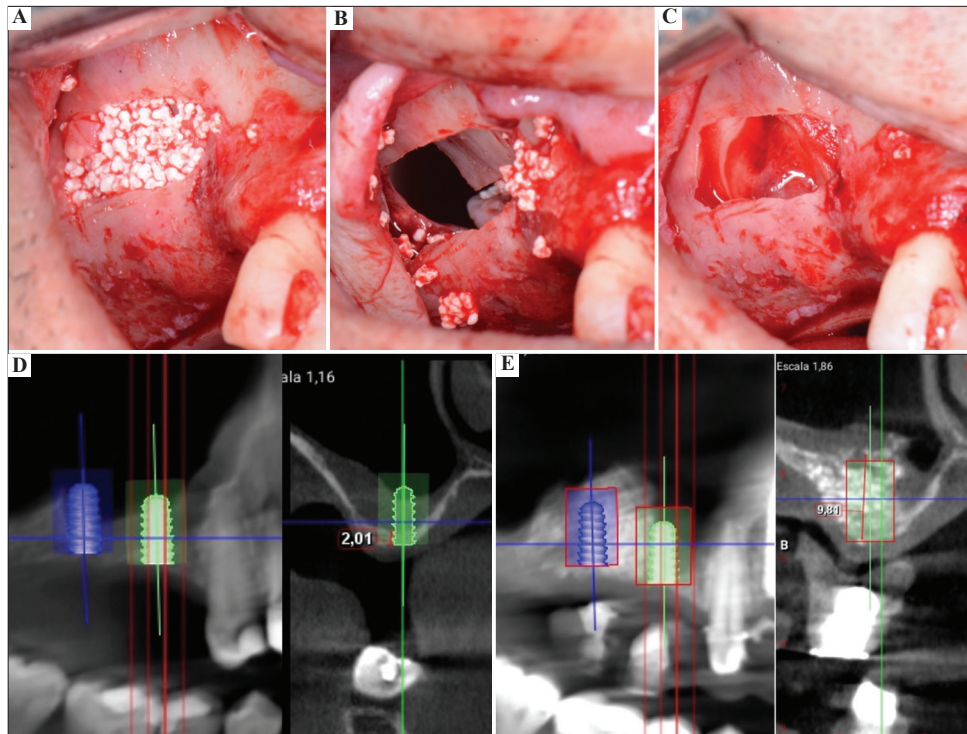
Patient no. 2. (A) After performing SLS and trying to fix a collagen membranes (CM) with a bone tack to seal the antrostomy. (B) The screwdriver was displaced, producing a perforation of the Schneiderian membrane Class IIA. (C) Two leukocyte and platelet-rich fibrin (L-PRF) membranes were immediately placed on the perforation site, and a CM was placed over these membranes to cover the area. (D) Initial cone-beam computed tomography (CBCT). (E) CBCT at 6 months post-surgery.
